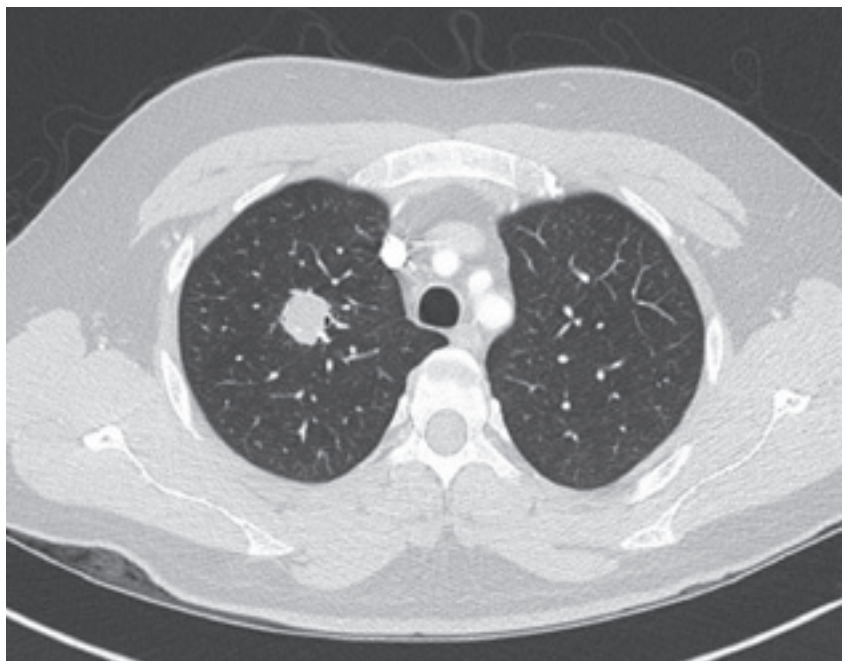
Image from CT chest scan showing 2-by-2.7-cm cavitating mass.
